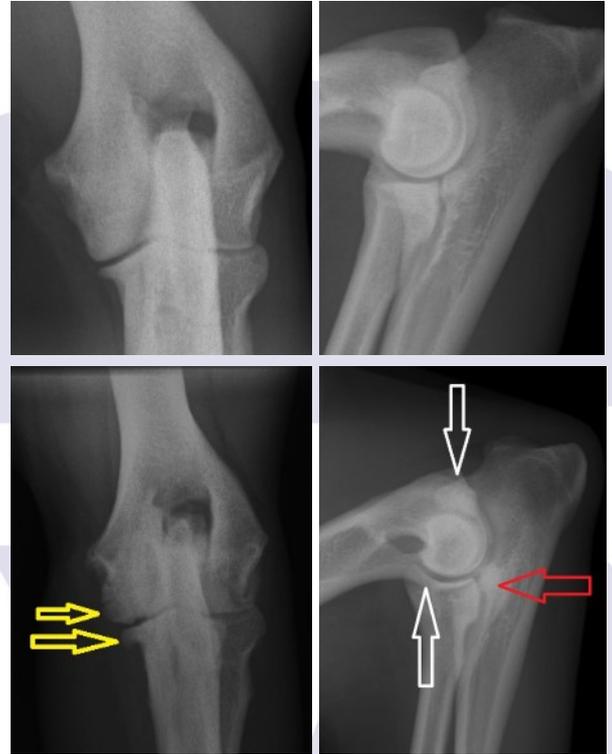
Top: Standard lateral and craniocauda radiographs of the normal elbow on the contralateral side. Bottom: Standard lateral and craniocaudal radiographs of the affected elbow . On the lateral radiograph, note the subchondral bone reaction (red arrow) and the abnormal shape of the radial head and anconeal proces (white arrow). On the Cranio-caudal view, note the periosteal bone reaction (osteophytosis) of the medial side of the joint. (yellow arrow)
